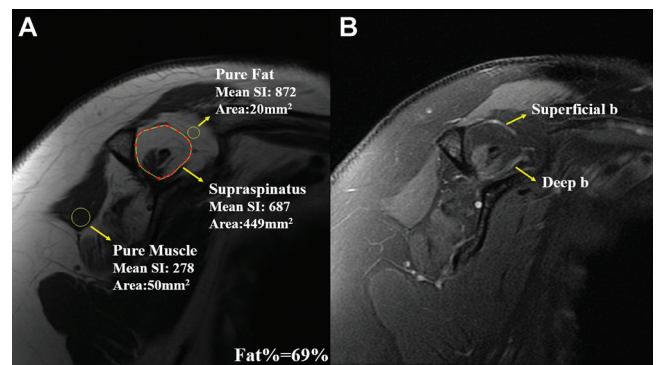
Preoperative (A) T1-weighted and (B) fat-suppressed proton-density T2-weighted scapular MRI Y view of right shoulder. Another example of our quantitative method. Fat% is 69% for this patient. b, branch; SI, signal intensity.
